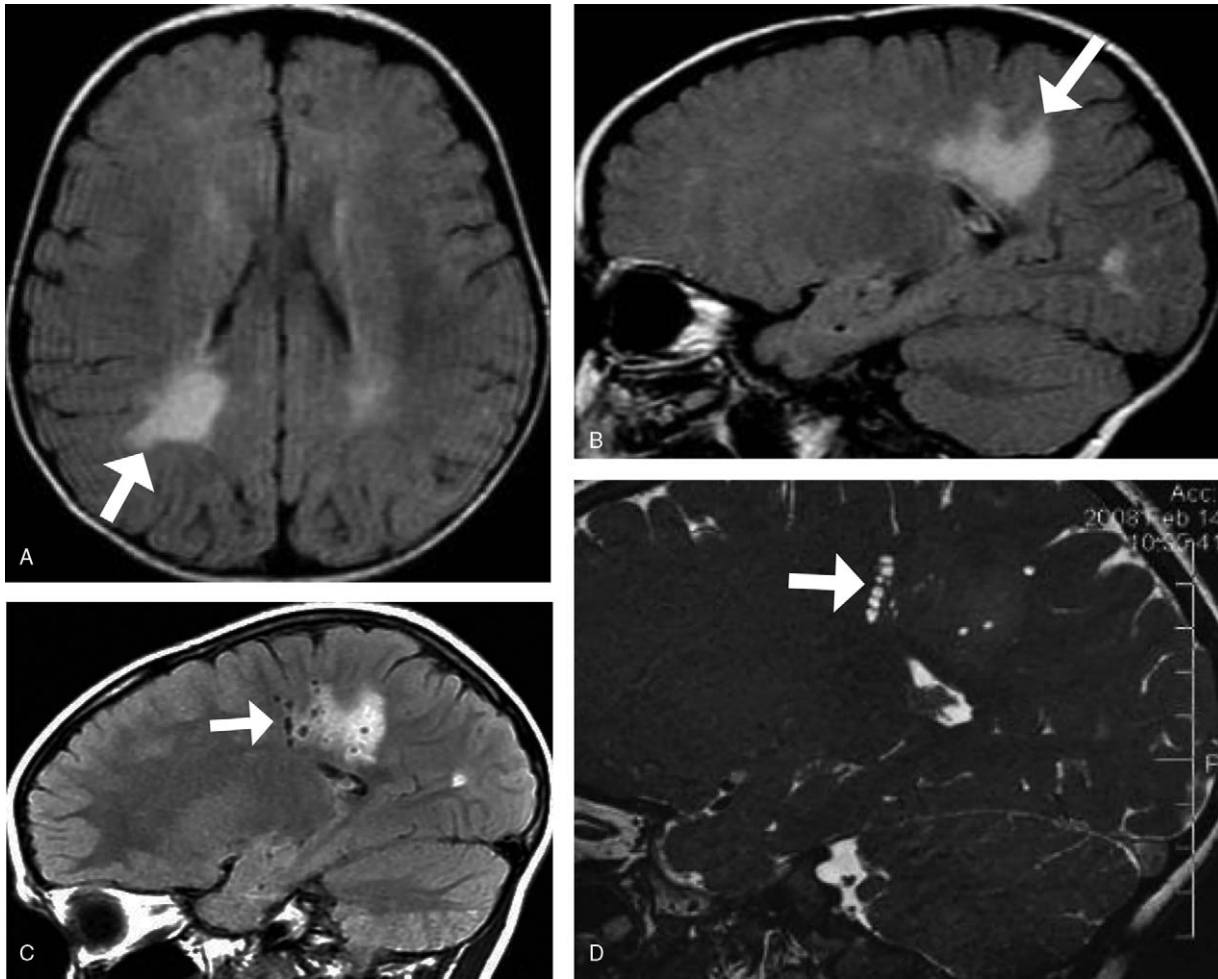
1-Year-old infant with hypomelanosis of Ito. Axial (A) and sagittal (B) T2-FLAIR images show signal hyperintensity of the periventricular white matter, more prominent in the right parietal lobe (white arrows). Sagittal T2-FLAIR (C) and sagittal FIESTA (D) images after 2-year follow-up show prominent perivascular spaces within the periventricular and subcortical white matter of the right parietal lobe (white arrows).
